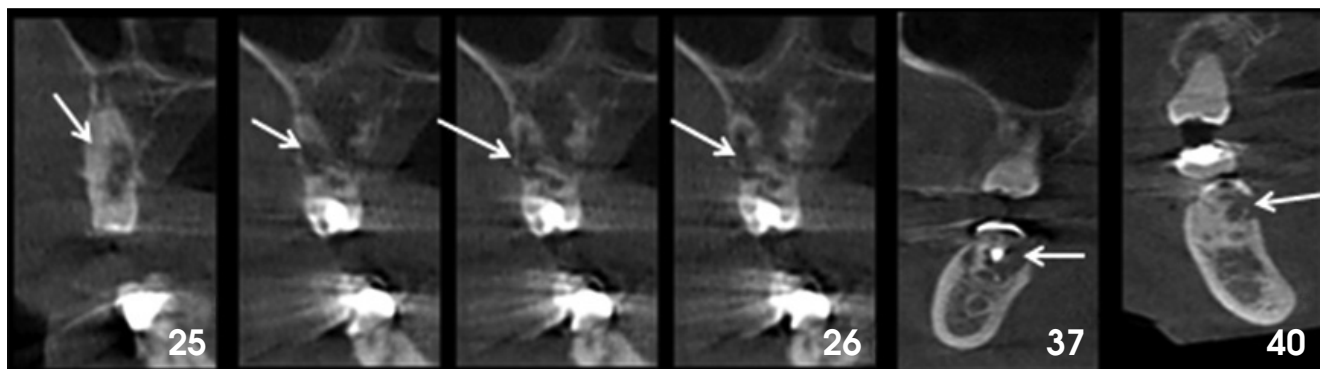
Cross-sectional cone-beam computed tomographic images show internal resorption in molar teeth (arrows).
